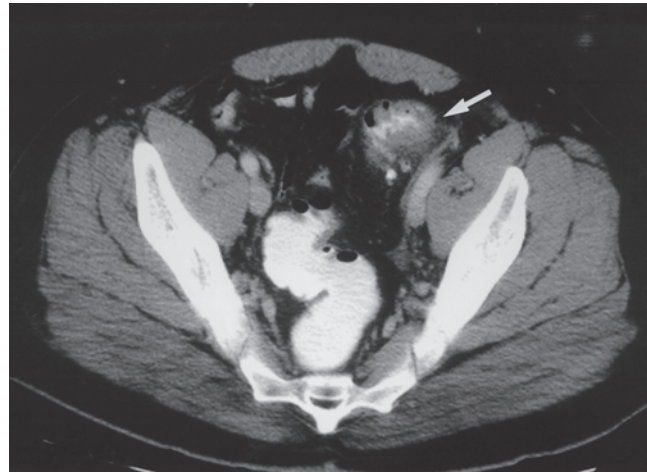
Computed tomographic scan shows thickening of the sigmoid colon (arrow) caused by acute diverticulitis.
